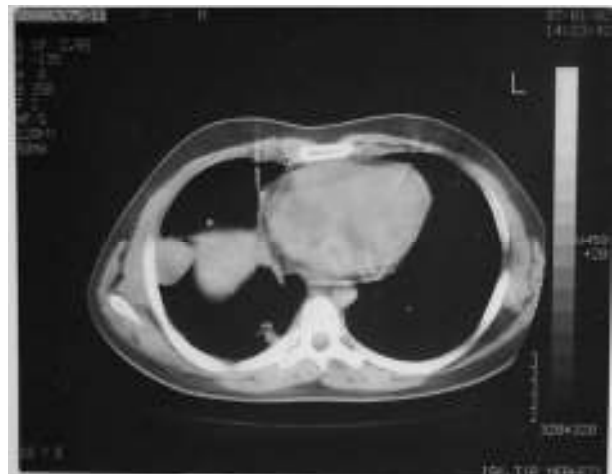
Chest computed tomography shows multiple pulmonary nodules in the right and left lung, mass at the right hilar paracardiac region and some areas pleural thickening.
